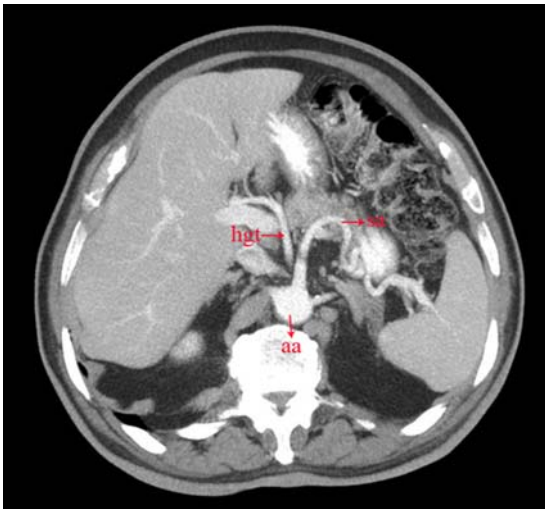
Hgt: Hepatogastric trunk; sa; splenic artery, aa; abdominal aorta. Splenic artery directly arises from the abdominal artery and hepatogastric trunk arises from the abdominal artery as seen in the CT image.
